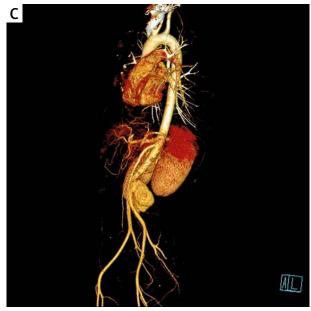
Computed tomography angiography images at presentation. A – Sagittal view of the pseudoaneurysm showing anterior displacement of abdominal aorta. B – Erosion of L3 due to compression of aortic pseudoaneurysm. C – 3D reconstruction of CTA showing pseudoaneurysm close to iliac bifurcation
